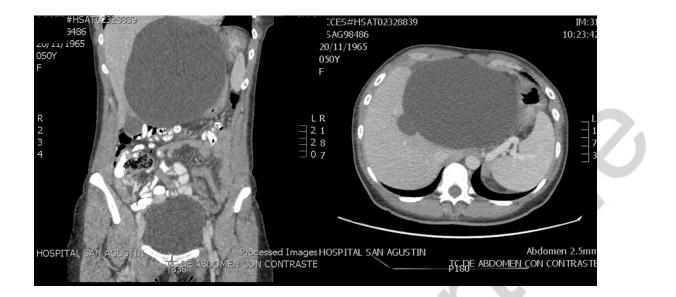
Abdominal CT scans showing a space-occupying lesion of the liver exerting a mass effect on neighboring structures and resulting in compression of the splenoportal axis.
